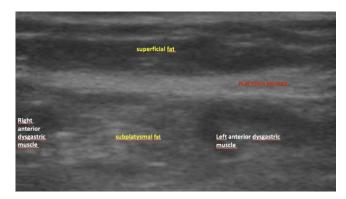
Ultrasound image with 10 mHz showing the anatomy of the submental region and its structures, with evidence of both superficial and deep fat, demarcated by the platysma muscle.
